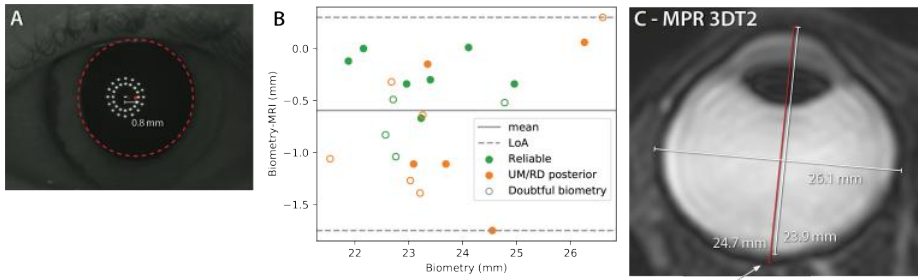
Evaluation of the optical biometry and MR-based axial length determination. (A) Pupillometric image of a UM patient, showing a relatively large decentration of 0.8 mm between the iris centre (red dashed line) and the line of sight (middle bright spot) along which the axial measurement was performed. (B) Difference between MRI-based and biometry-based eye length measurements. In patients with a doubtful biometry (open dots) an average 0.7 mm shorter eye was measured with the biometry, while in patients with a UM or retinal detachment (RD) in the posterior pole (orange dots) on average 0.8 mm shorter measurements were found. For the remaining patients (filled green dots), there was generally a good agreement between both techniques, except for one patient where part of the sclera was included in the MRI measurement (C). (C) The original MRI-based eye length measurement (red) of the patient that showed a 1.4 mm larger eye length than on biometry. A re-evaluation of the MRI showed that part of the sclera (arrow) was erroneously included in the MR-measurement, causing the overestimation of the eye length with 0.8 mm.
